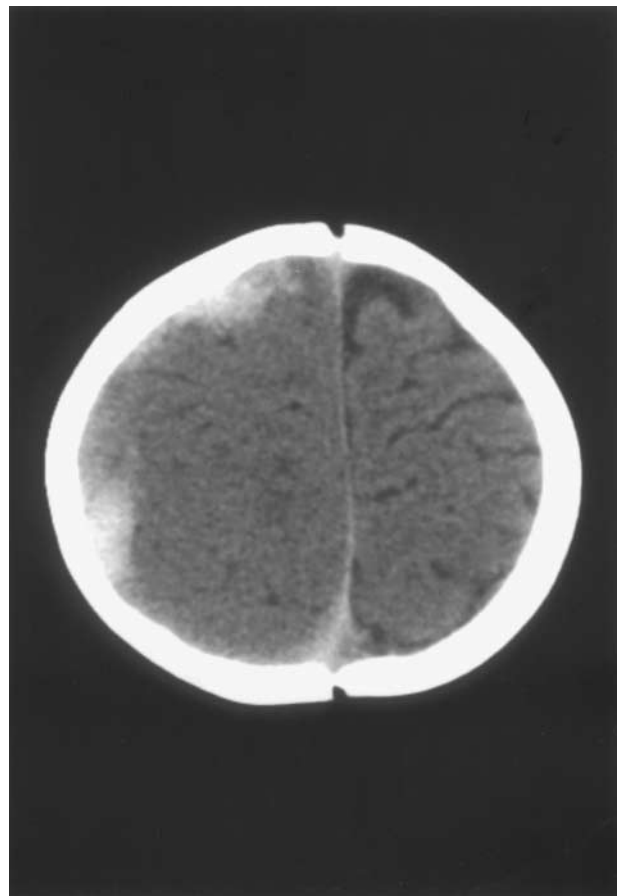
On the Evening His Nonacute Subdural Collection Was Identified, This 11-Month-Old Child Fell From His Hospital Bed. Although He Suffered No Acute Loss of Consciousness, He Appeared Less Active Following the Fall and Became More Lethargic Over the Next Few Hours. Late That Evening, He Manifested Intermittent Periodic Breathing and Bradycardia. Urgent Cranial CT Scan Revealed Increased Swelling of the Right Hemisphere, Acute Subdural Rebleeding on the Right, and Worsening Mass Effect With Increased Midline Shifting. Neurosurgical Intervention Confirmed Acute Subdural Rebleeding.
